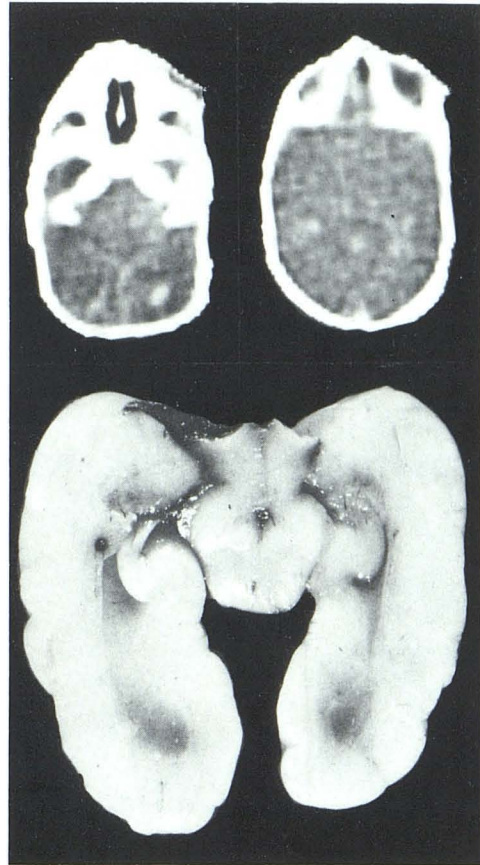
Subependymal and intraventricular hemorrhage, premature neonate, 27 weeks, birth weight 620 g. Death at 4th day from perinatal asphyxia caused by immaturity. CT: small left temporooccipital paraventricular hematoma, slight intraventricular hemorrhage in occipital horns. Autopsy: small subependymal hematoma. Rupture of ependyma, but no detectable intraventricular hemorrhage.
